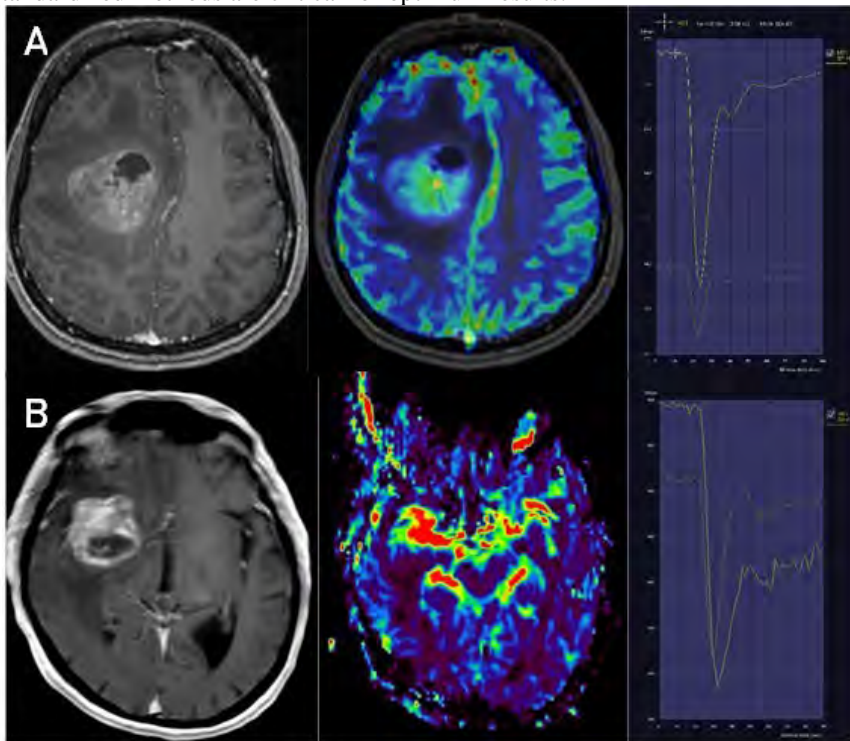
Imaging of two brain tumors on contrast-enhanced T1-weighted sequence and on a DSC perfusion map. The rightmost panel shows the peak signal intensity recovery (PSR) curve, a hemodynamic metric derived from the DSC perfusion map. (A) shows a glioblastoma (GBM). Note that after first pass of contrast agent signal intensity almost returns to baseline. (B) shows metastatic gastric adenocarcinoma. After contrast passage signal intensity remains below baseline, indicating leakage of blood brain barrier, as typically seen in BM.
